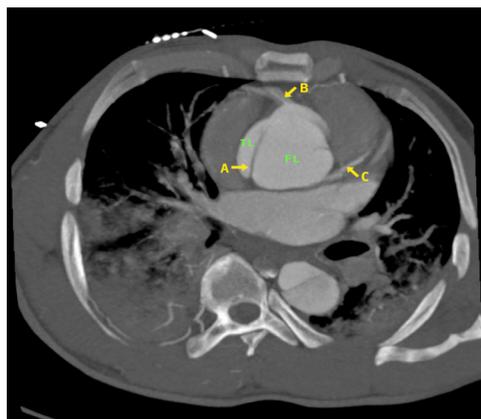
Computed Tomography Angiography showing proximal ascending aorta with intimal flap (A) at the root of the aorta separating the false lumen (FL) from the true lumen (TL) involving the right coronary artery (B) and left coronary artery (C).
